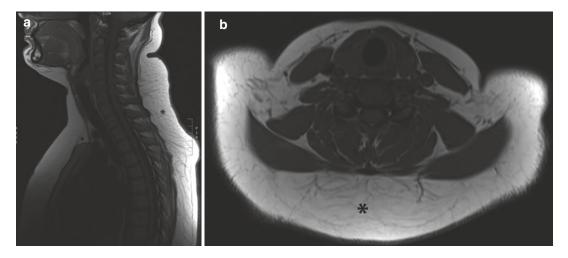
(a, b) Madelung disease. (a) Sagittal SE T1-weighted MR image. (b) Axial SE T1-weighted MR image of the neck. Diffuse fatty deposition (*) throughout the subcutaneous tissues in the neck
